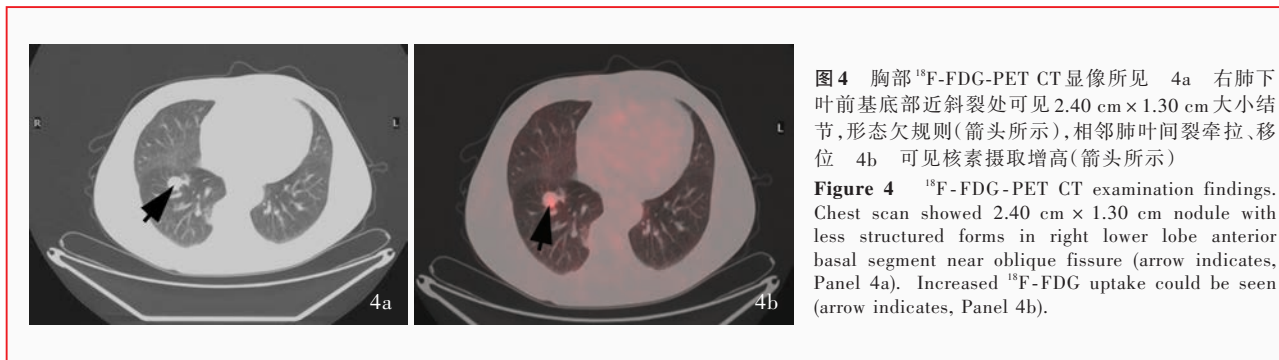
胸部¹⁸F-FDG-PET CT显像所见 4a 右肺下叶前基底部近斜裂处可见2.40 cm × 1.30 cm大小结节,形态欠规则(箭头所示),相邻肺叶间裂牵拉、移位 4b 可见核素摄取增高(箭头所示)
